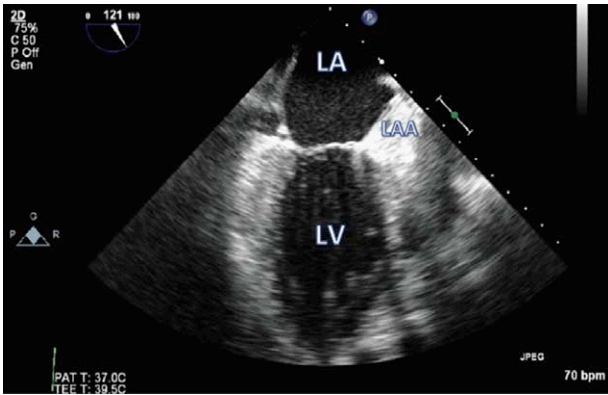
A transesophageal image of the left atrial appendage after closure using a suture snare LARIAT device. LA indicates left atrium; LAA, left atrial appendage; and LV, left ventricle.
